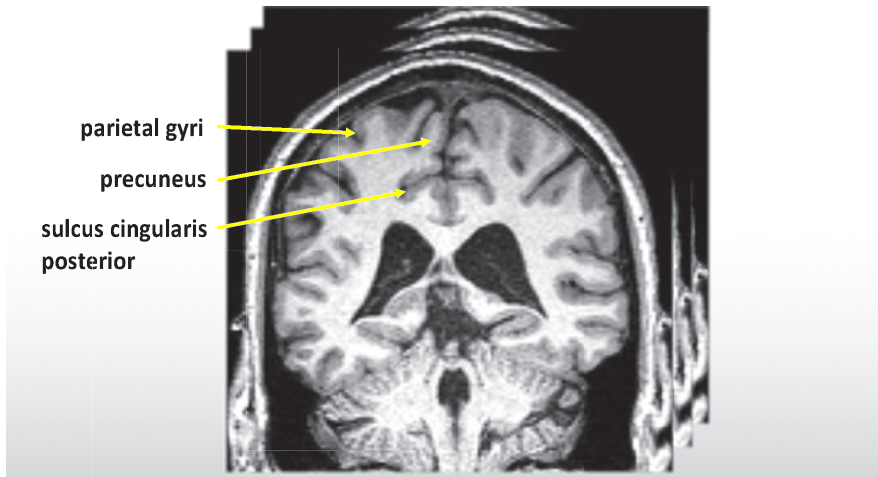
Three structures assessed using Parietal Atrophy Score (PAS) on T1-weighted coronary slices in the range of whole parietal lobes on brain magnetic resonance imaging
